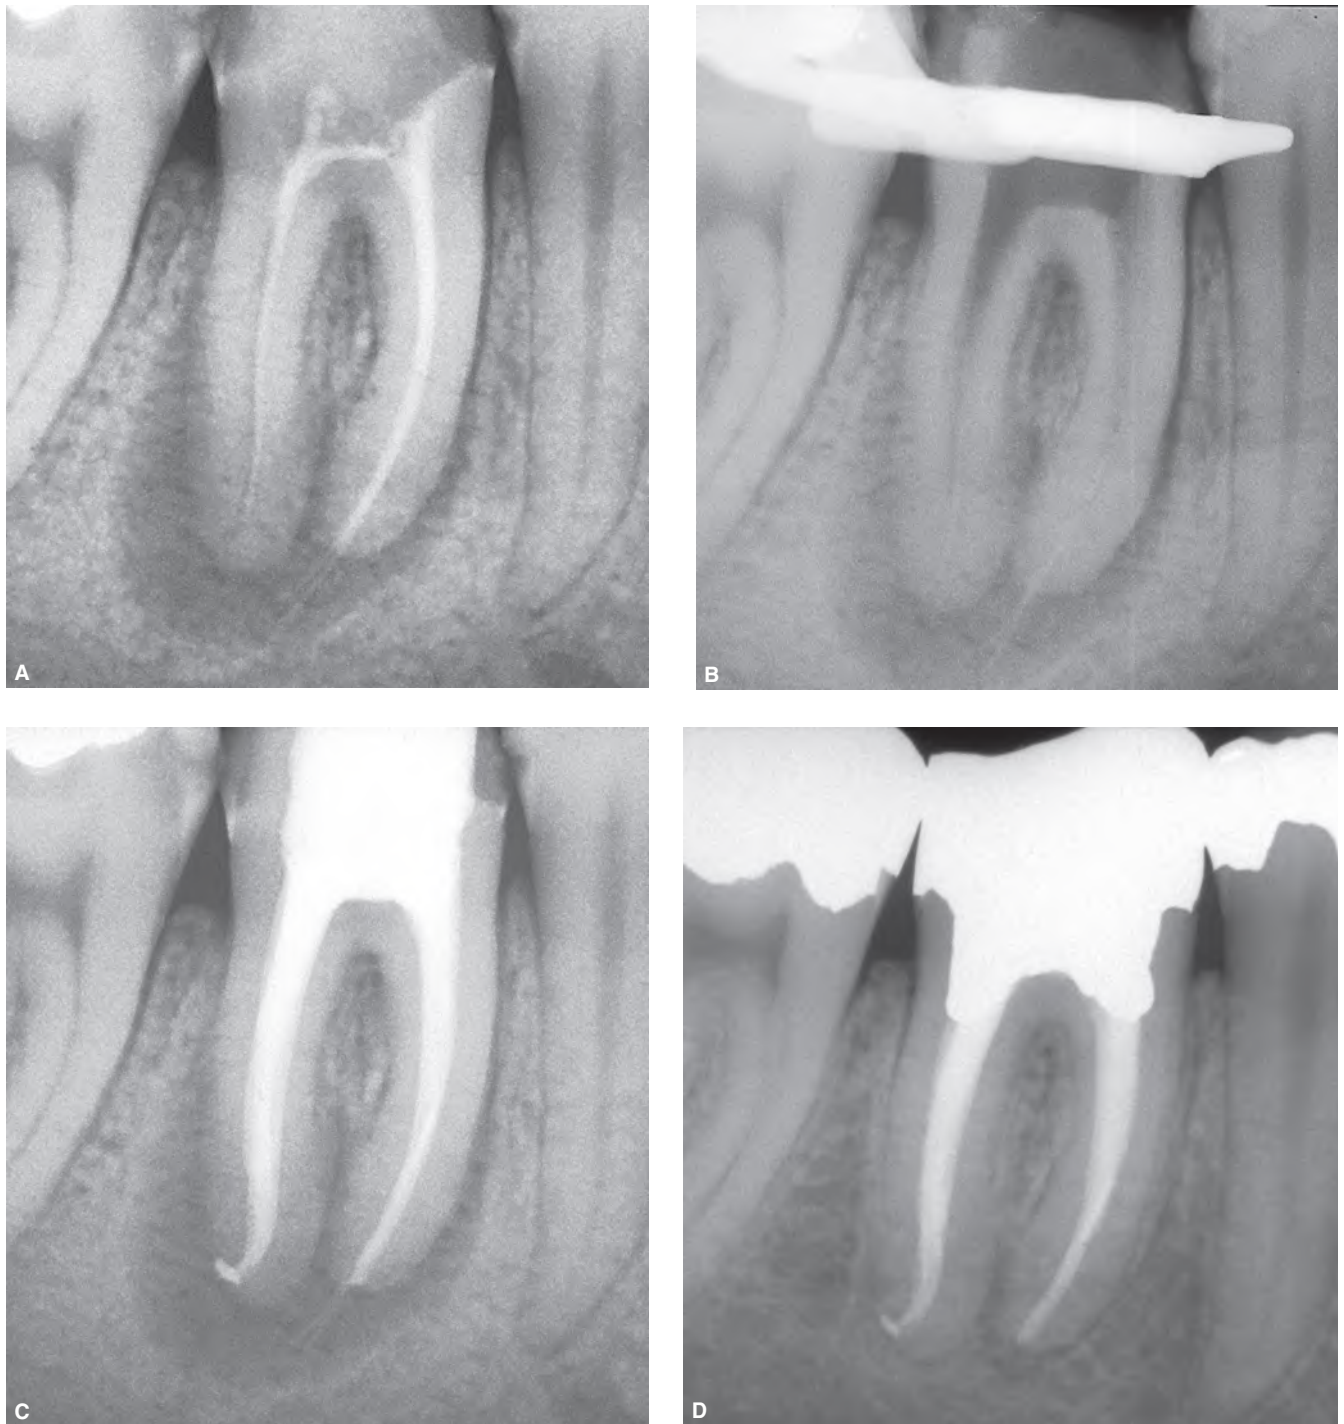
A. Preoperative radiograph showing an improperly treated mandibular right first molar. The distal canal is under-filled and the mesial canals have gutta-percha cones overextending into the periapical tissues. B. Intraoperative radiograph showing a failed attempt to remove the gutta-percha protruding beyond the apical foramen. C. Immediate postoperative radiograph showing the two gutta-percha cones still present in the lesion. D. 3-year recall radiograph. The apical lesion has resolved and the two gutta-percha cones completely disappeared. The apical lesion was most probably caused by an infected root canal system and NOT by a foreign body reaction to the overextended gutta-percha.
